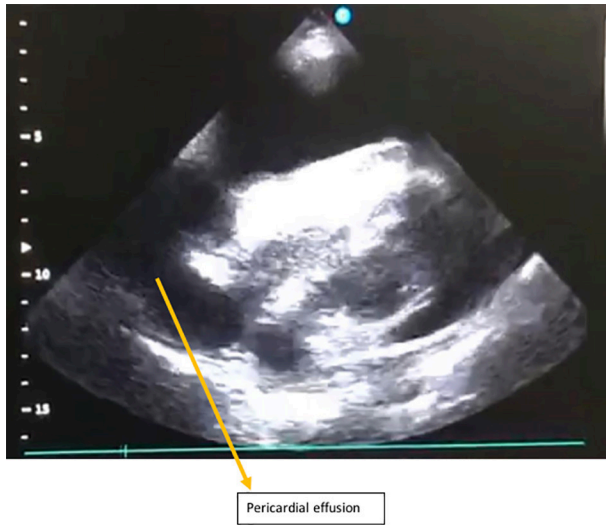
Echocardiography examination showed massive pericardial effusion.
